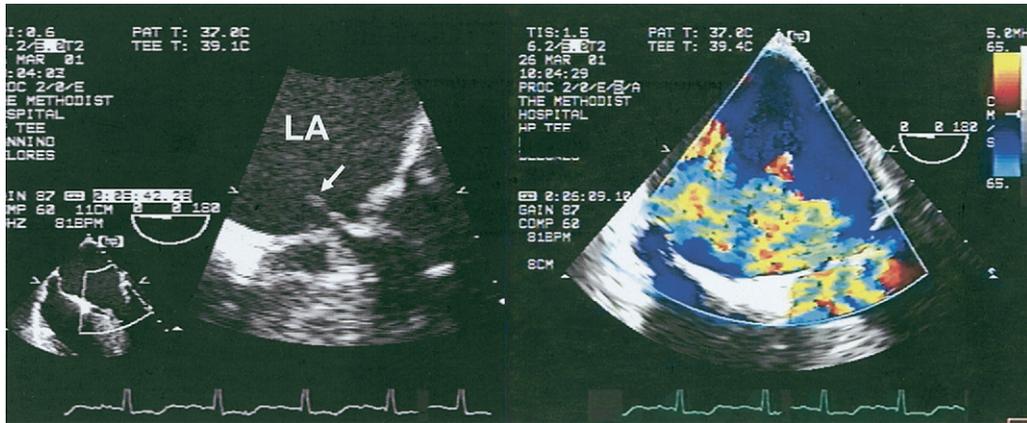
(Left) Flail segment of posterior mitral leaflet. (Right) Color Doppler with eccentric mitral regurgitation jet directed antero-medially. LA = left atrium.
